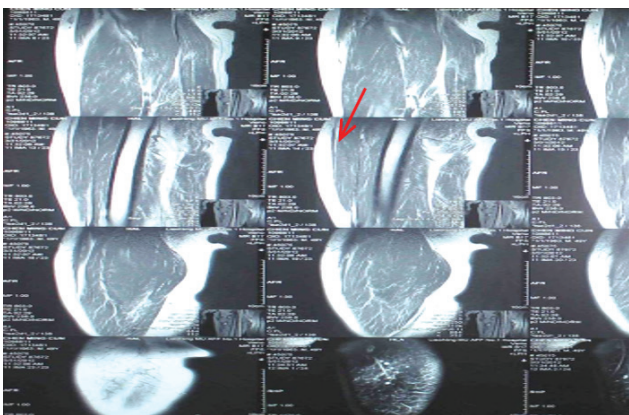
Sagittal MRI view showing degloving lesion at left proximal thigh near greater trochanteric region
